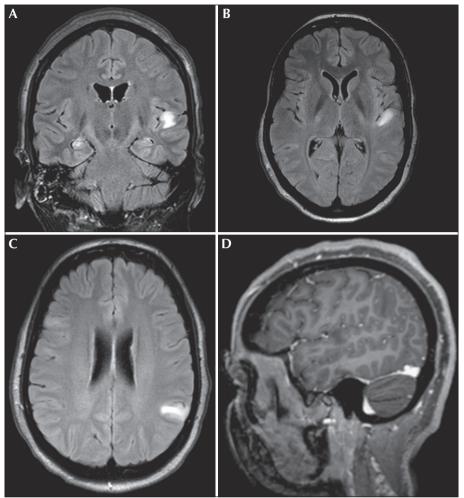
Magnetic resonance imaging shows multifocal brain lesions.
